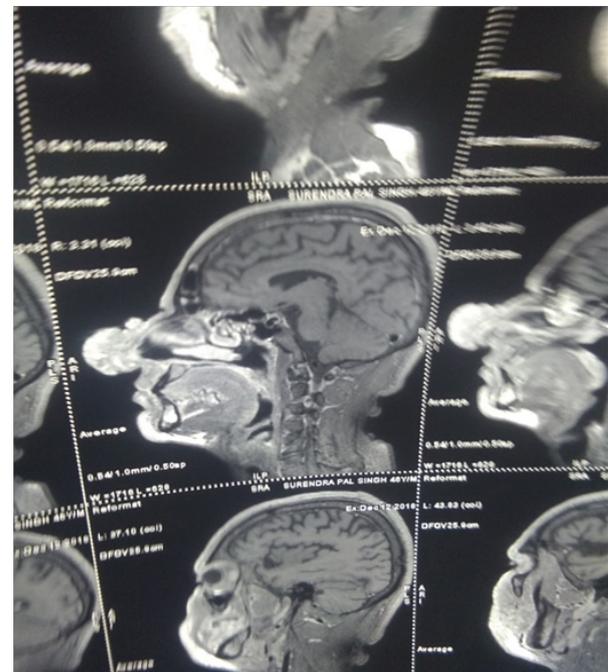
MRI scan reveals extensive cutaneous lobulated tumor with complete obstruction of the both nostrils.
